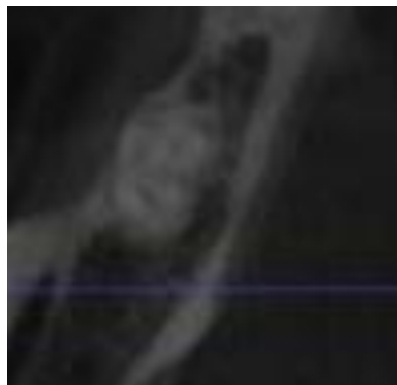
CBCT image of the C3-shaped canal in the mandibular right first molar (mid-axial section)
